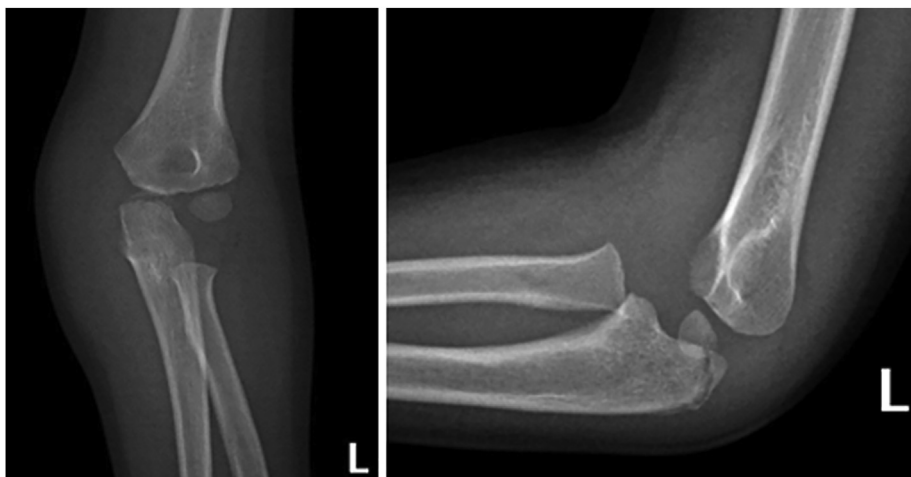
AP and lateral radiographs, left elbow at first presentation.
